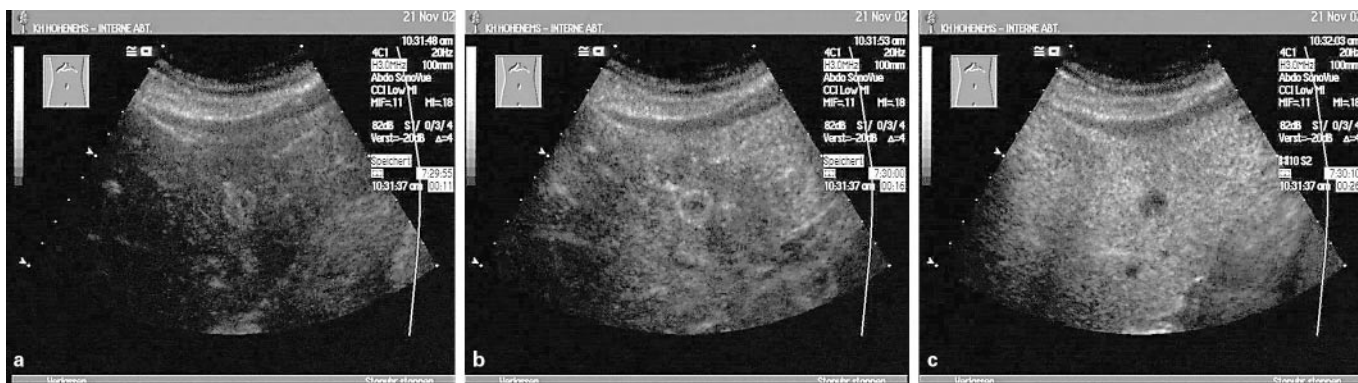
Metastasis with hypervascularisation in signal-enhanced ultrasound. 11 s after contrast agent injection a strong contrast agent uptake is visible (a), which becomes hypochoic 5 s later (b). 26 s after injection the lesion shows a complete lack of contrast enhancement (c).
